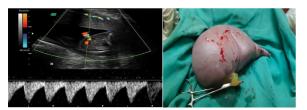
Doppler showing the reverse arterial flow
